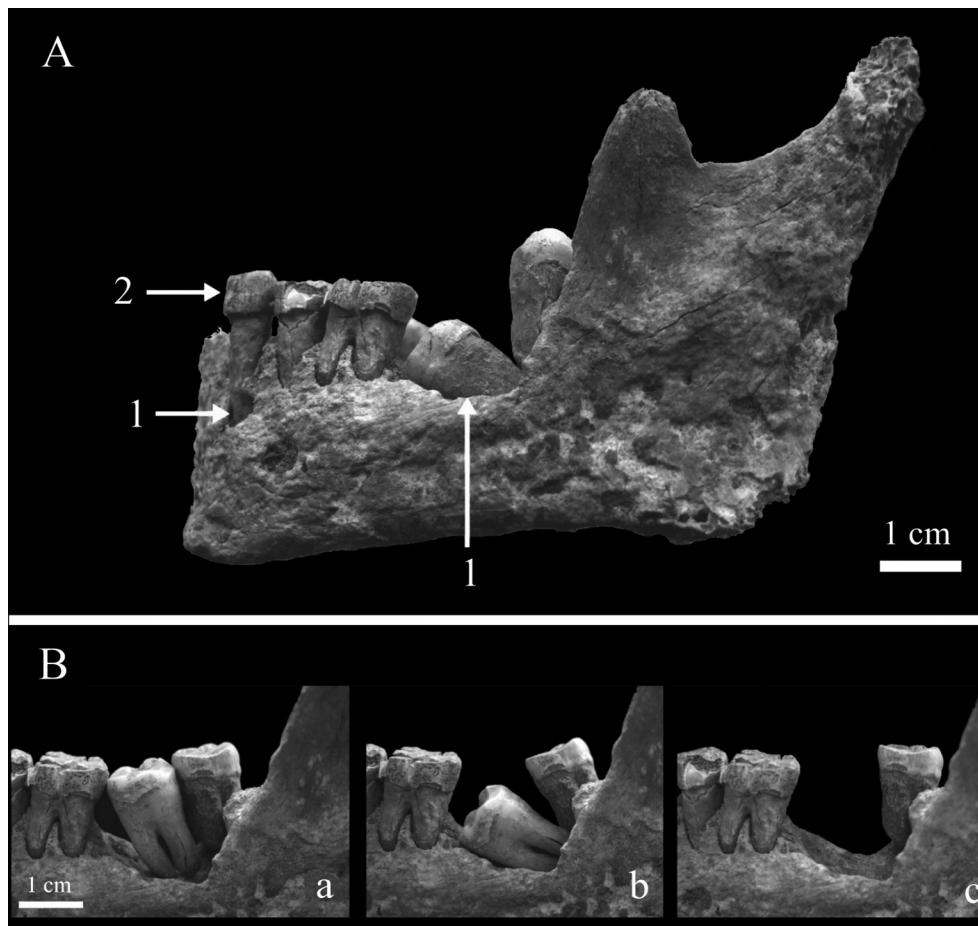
Mandibule de l'individu de la tombe 11 de Kindoki. A. Vue latérale gauche (1 = lésions périapicales, 2 = ligne d'hypoplasie de l'émail). B. Vues latérales gauches rapprochées. Deux scénarii (a et b) sont proposés en ce qui concerne la position de la seconde molaire ; a : la dent était encore plus ou moins dans sa position initiale ; b : la dent avait totalement basculé sur sa face mésiale ; c : vue de la cavité sans la deuxième molaire / Mandible of the individual from grave n° 11 at Kindoki. A. Left side view (1 = periapical lesions, 2 = enamel hypoplasia line). B. Close-up lateral views. Two hypotheses (a and b) are proposed concerning the position of the second molar; a: the tooth was still more or less in its original position; b: the tooth had twisted entirely onto its mesial face; c: view of the cavity without the second molar
